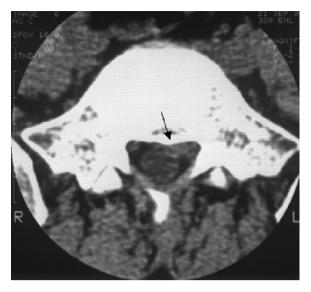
The CT scan after the treatment. The arrow showed size and position of L5–S1 lumbar disc herniation after the treatment at the 12 months.
